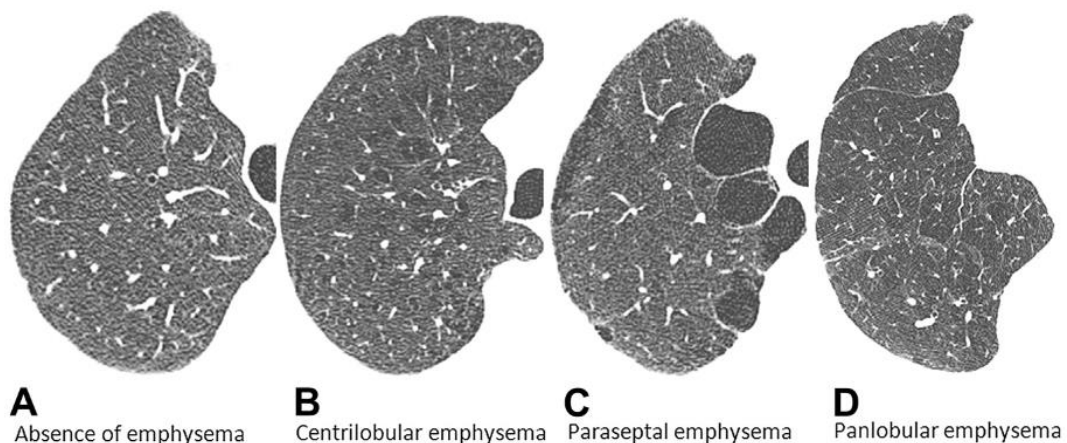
Computed tomography images for normal and different emphysema types, taken from: Smith, B.M., et al., Pulmonary emphysema subtypes on computed tomography: the MESA COPD study. The American journal of medicine, 2014. 127(1): p. 94. e7-94. e23.
